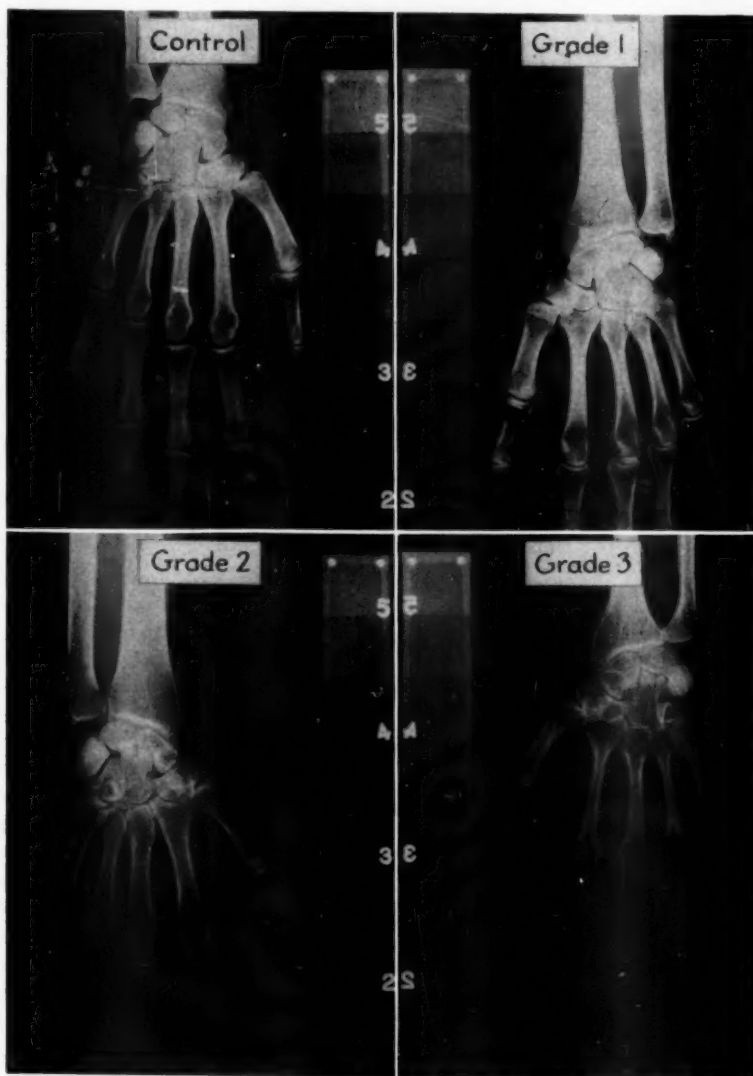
X-rays of the bones of the hand with the aluminum ladder in place. These show equal densities of the aluminum ladder, and the variations in bone density in the Control, Grade 1, Grade 2, and Grade 3 osteoporosis.
